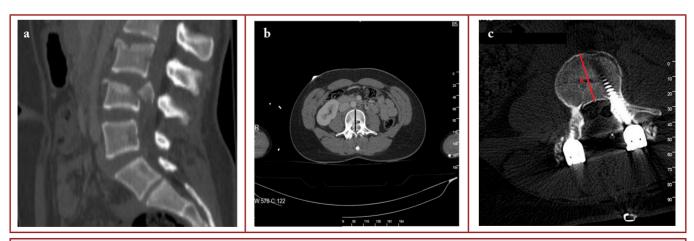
a) Preoperative sagital computed tomography scan of Lumbar 3 burst fracture b) Preoperative axial computed tomography scan of Lumbar 3 burst fracture. a: The distance between the most fore part of the vertebra body and most hind part of the retropulsed fragment. c) Postoperative axial computed tomography scan of Lumbar 3 burst fracture. b: The distance between the most fore part of the vertebra body and most hind part of the retropulsed fragment after ligamentotaxis with impaction.
